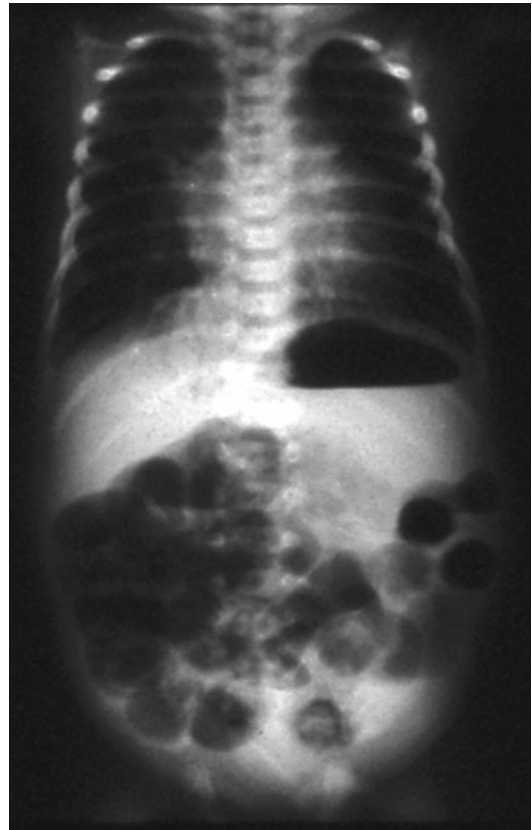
Abdominal plain film in newborn with NEC: portal venous gas seen as a radiolucency linear band in the right hypochondrium on the opacity
